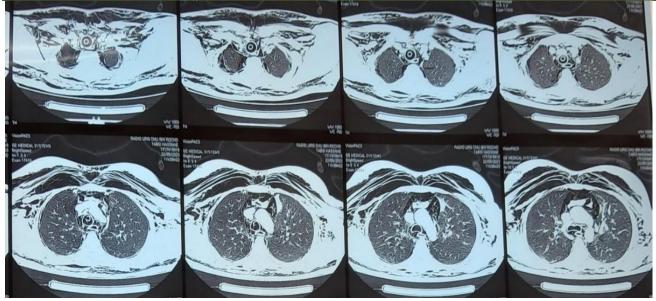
Chest CT scan in axial section and parenchymal window, showing subcutaneous emphysema, moderate pneumomediastinum and right pneumothorax
